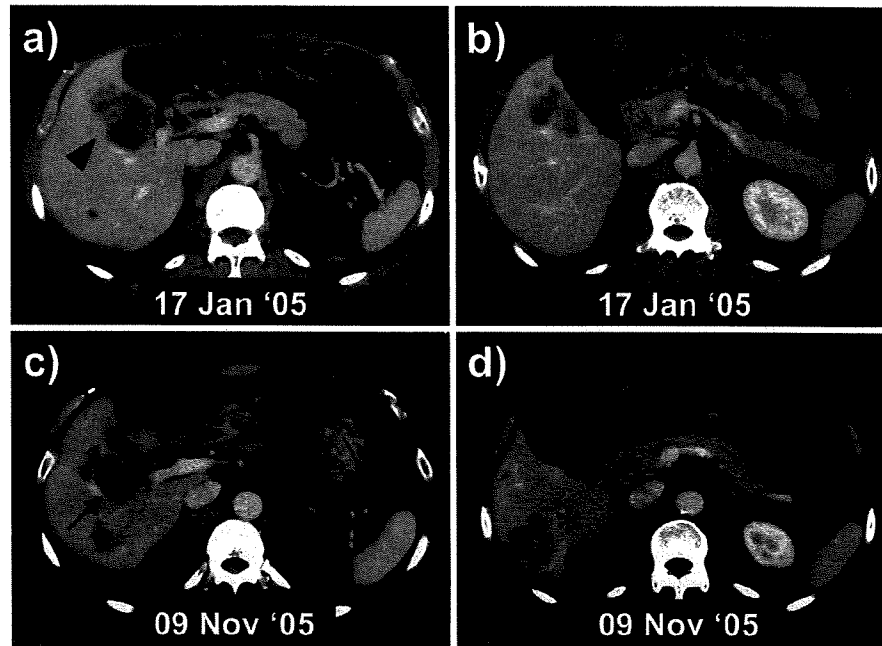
The contrast-enhanced CT image presented huge cystic and multilocular lesions. a, b) In the anterior segment of the right lobe, a huge and low-attenuated mass (arrowhead) and some tiny hypodense lesions were detected. c) The corresponding lesion in the anterior segment migrated into the center of the right lobe (arrow). d) A multilocular lesion (asterisk) was newly detected in the posterior segment of the right lobe.
